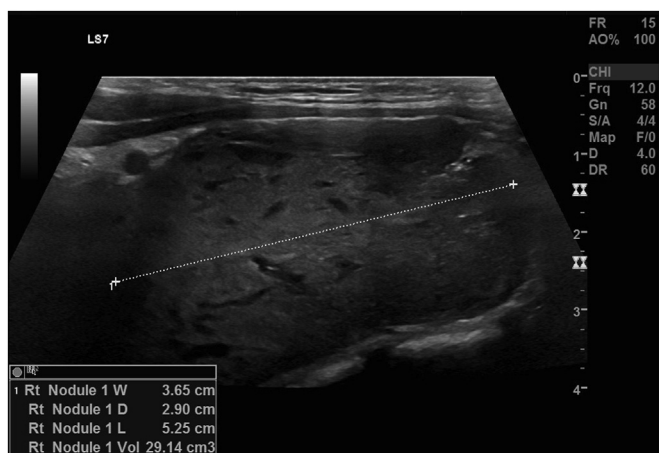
Sagittal view of preoperative paraganglioma on ultrasound.
